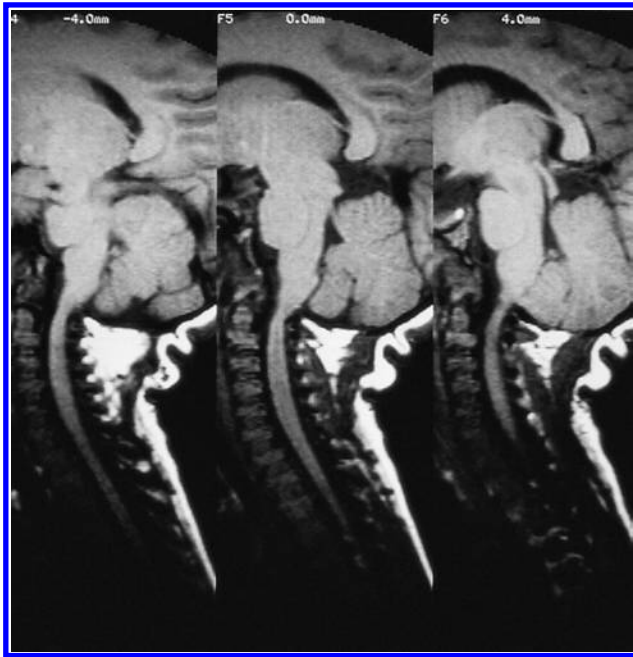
Magnetic resonance image of RF, a patient with multiple sulfatase deficiency. A localized quite marked constriction of the anteroposterior diameter and compression of the cord to about one-half of normal size.
